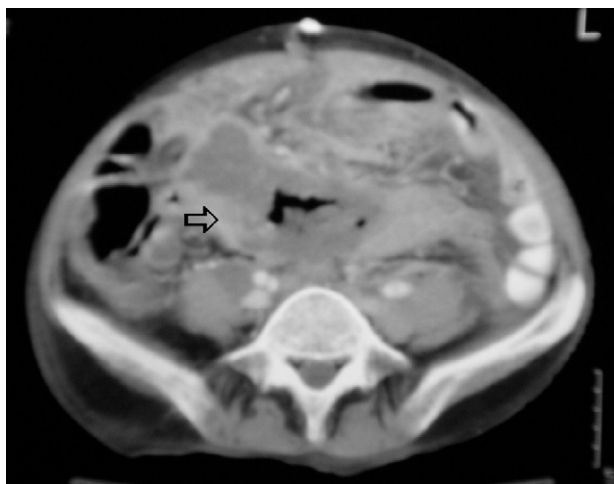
Computed tomography (CT) scan shows a large intra-abdominal mass with air-fluid levels within, and soft tissue density along its walls surrounded by distended bowel loops.
